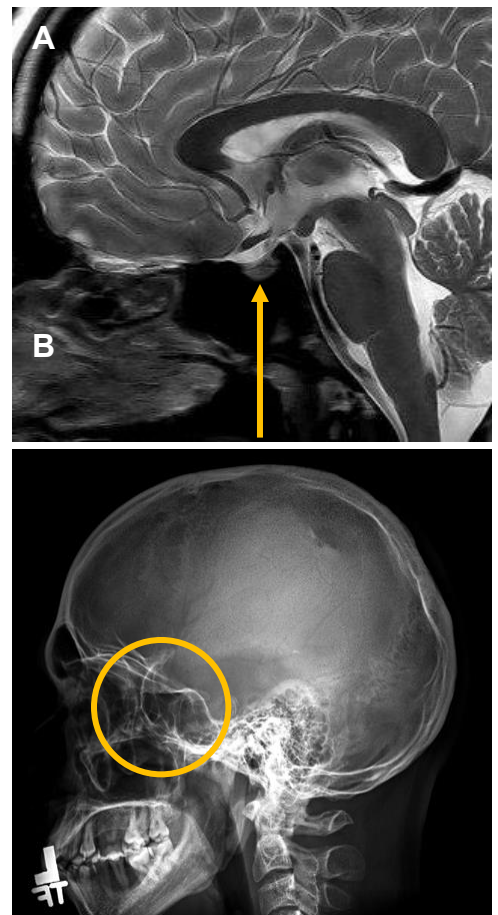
(A) Sagittal T2W high resolution image of the brain displaying the pituitary gland within the sella turcica, which is hypointense and invisible (arrow). (B) Lateral radiograph of the skull demonstrating the bony structure of the sella turcica (circle). *Courtesy of Toshiba America Medical Systems.*
